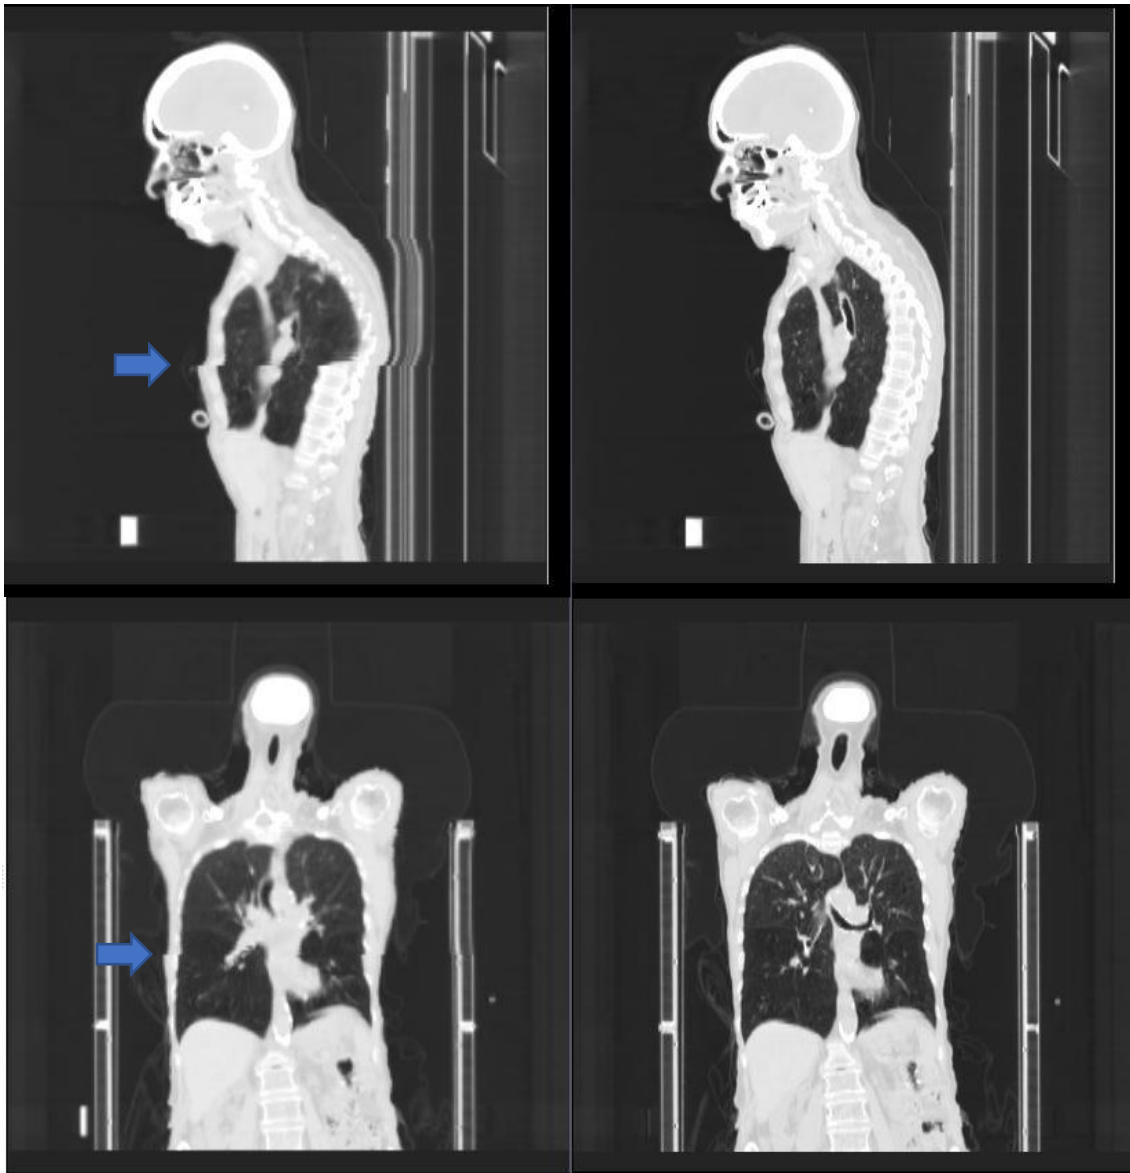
Displacement of the deformed portion of CT exported from RTapp™ and the planning CT of patient RTAT 33B6 in fraction 4.
